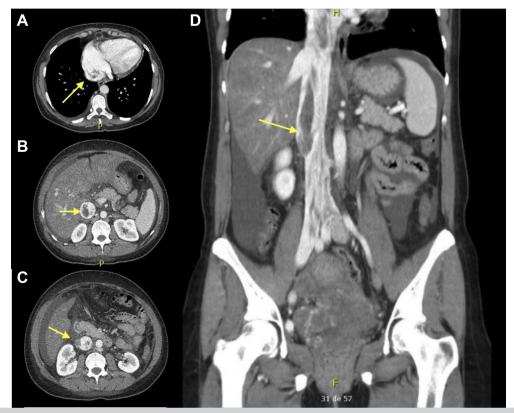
(A-C) Axial image of an abdomen and Pelvis computed tomography scan at the level of the right atrium, inferior vena cava (IVC), and right ovarian vein. Intraluminal material visualized within the IVC consistent with intravascular tumor (*yellow arrows*). (D) Coronal image of abdomen and pelvis CT scan at the level of the IVC. Intravascular leiomyomatosis (IVL) is marked with a *yellow arrow*.
